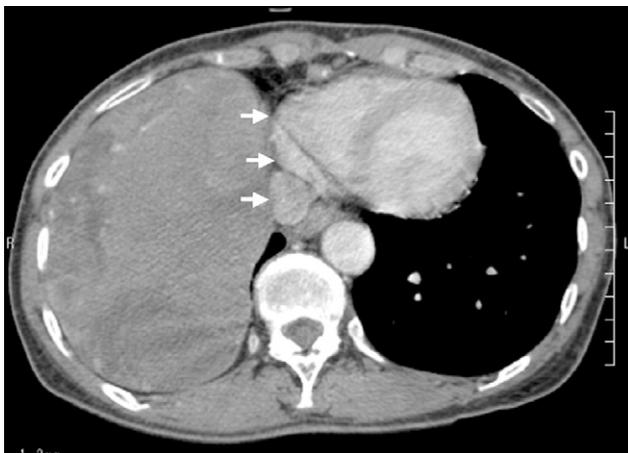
Enhanced computed tomographic scan at the level of the diaphragm shows a huge inhomogeneous mass and left-side deviation of the lower mediastinum (arrows).
